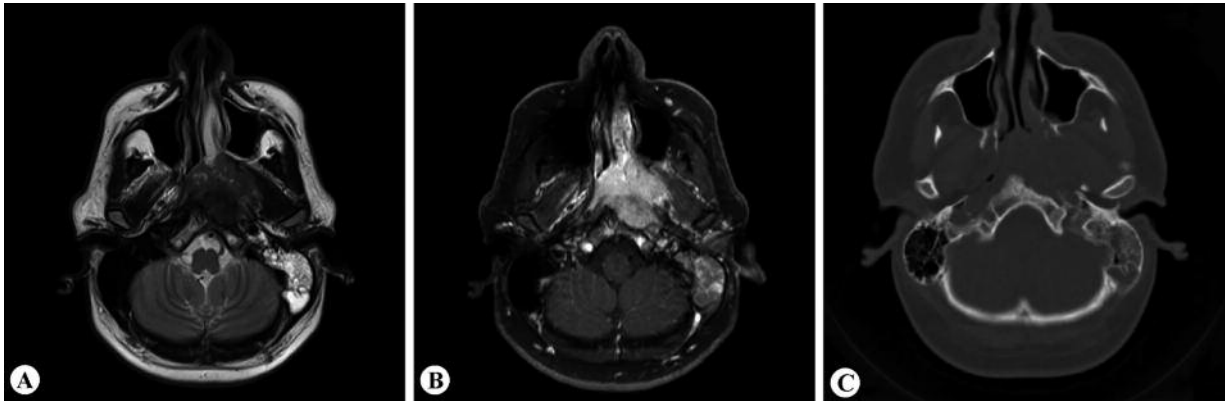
A-C, Axial T2- weighted MRI, post-gadolinium fat suppressed axial T1-weighted MRI and axial CT image demonstrates a large mass lesion filling the nasopharynx, invading the clivus with extension into the left parapharyngeal space and left nasal cavity. Note fluid in the left mastoid air cells.
